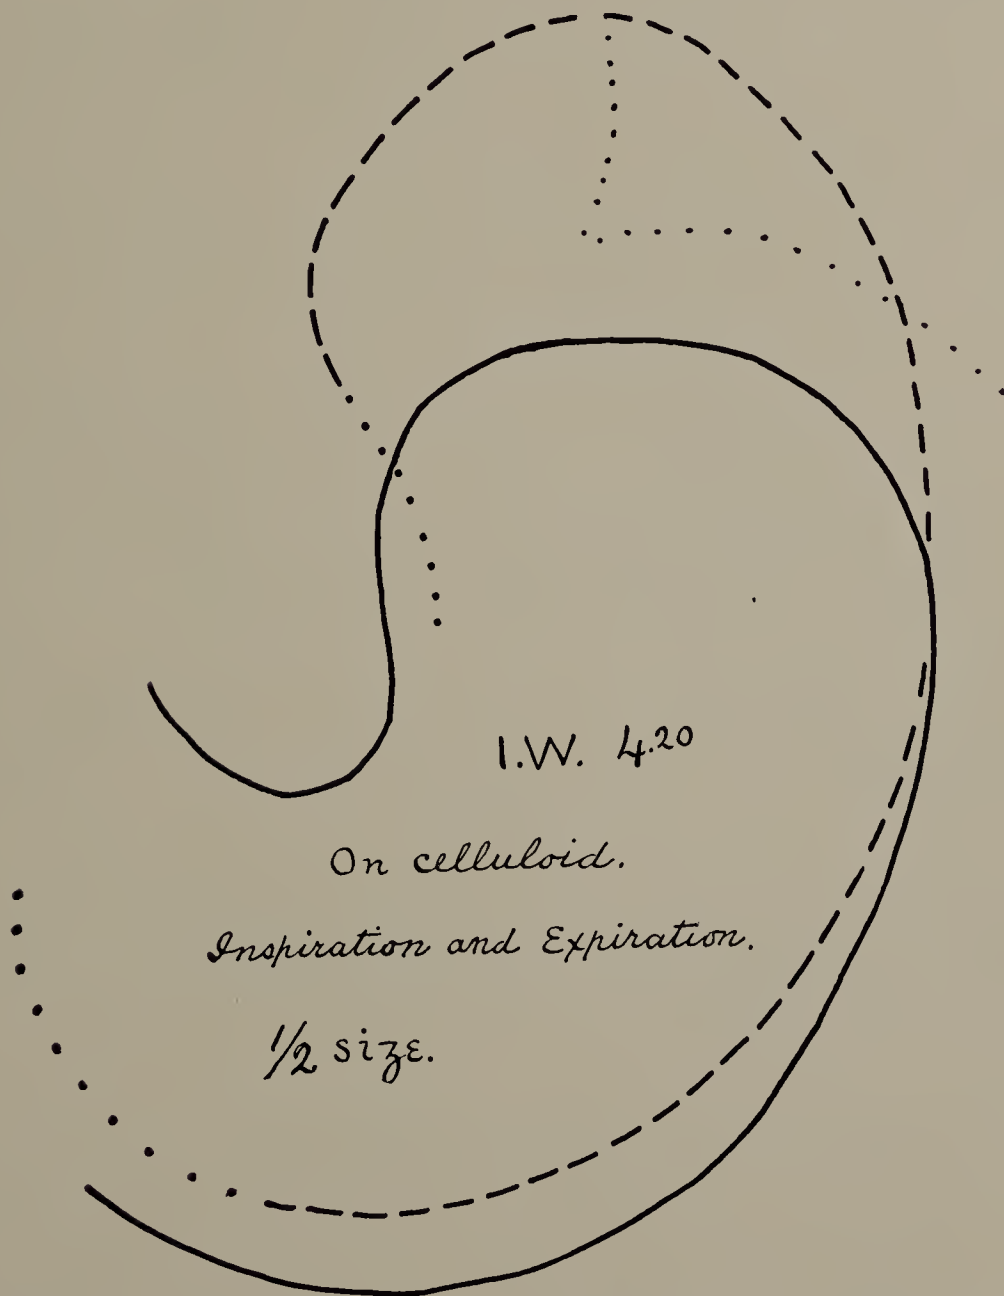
James W. Cut of X-ray tracing. 4.20 P.M. Broken line shows size and position of stomach in expiration; full line, in deep inspiration.
